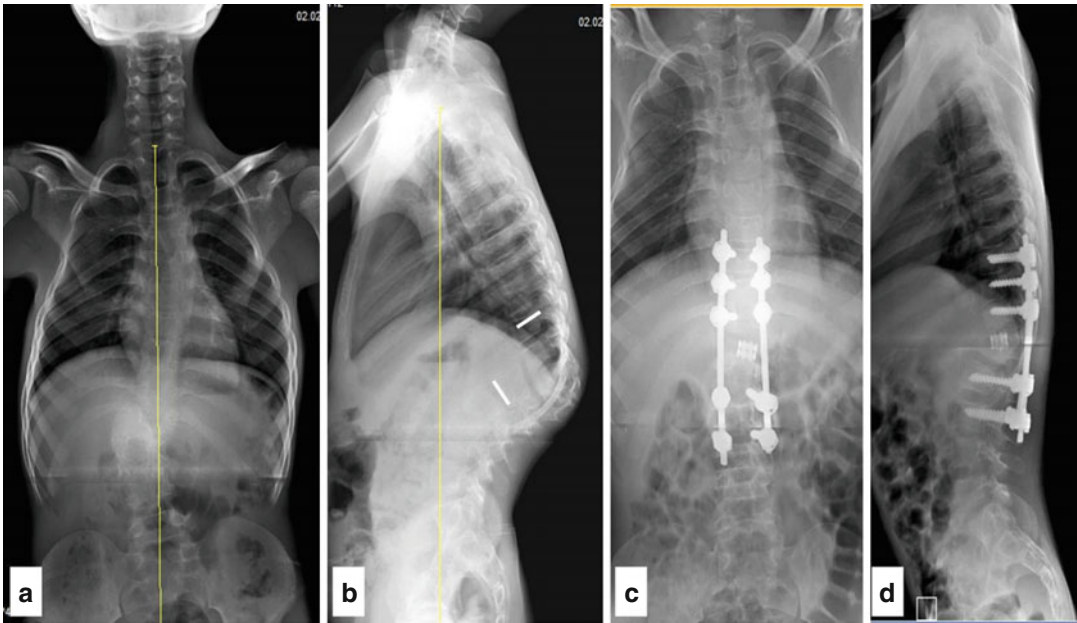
Closing opening wedge osteotomy to correct a post tubercular kyphotic deformity. (a, b) Pre-operative AP, lateral radiograph of the patient shows a kyphotic deformity of 118 degrees at the thoraco-lumbar junction between T9 and L3 vertebrae (marked between the two white lines). The yellow
